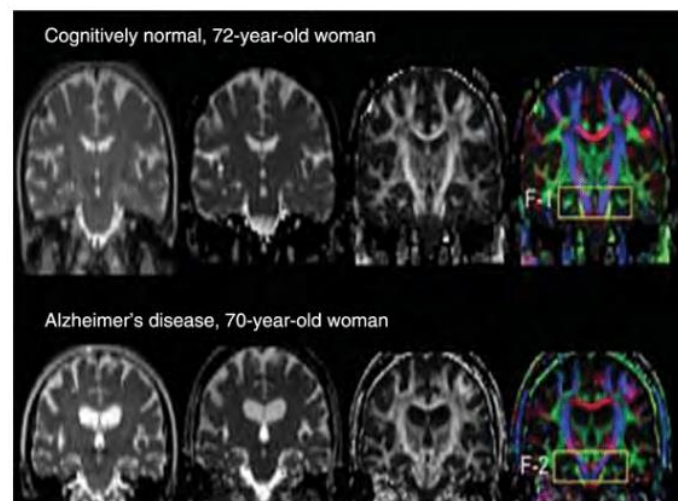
3 typical diffusion tensor imaging (DTI) of the brain of an Alzheimer's disease patient compared to a cognitively normal individual. (a) Conventional MRI images of a 72-year-old cognitively normal woman and a 70-year-old Alzheimer's disease patient. (b) Mean diffusivity (MD), (c) fractional anisotropy (FA) map, and (d) color coded FA for each MRI scan. A significant difference is observed in the cingulum hippocampal area of brain (labeled F-1 on the cognitively normal image and F-2 on the Alzheimer's disease image). (Adapted from Oishi, K., Mielke, M.M., Albert, M., Lyketsos [39].
